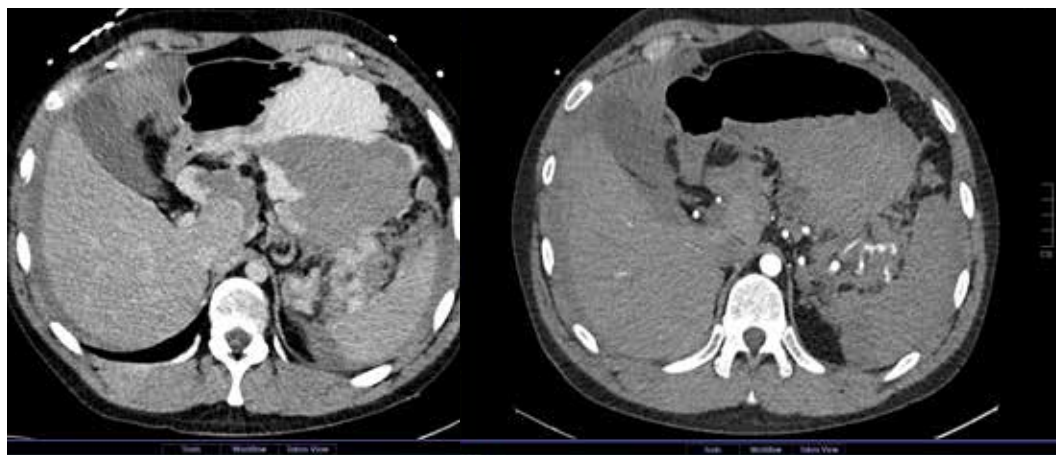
CT scan at admission.
